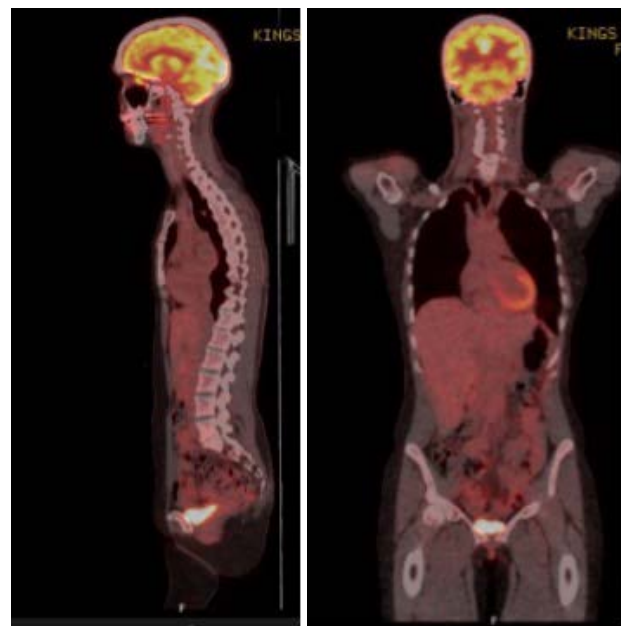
Sagittal and Coronal Plane of PET-CT scan.
